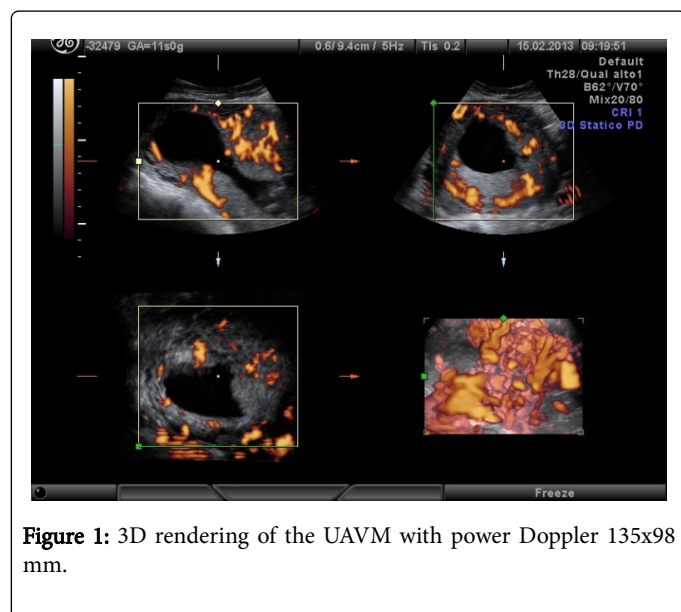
3D rendering of the UAVM with power Doppler 135x98 mm.
